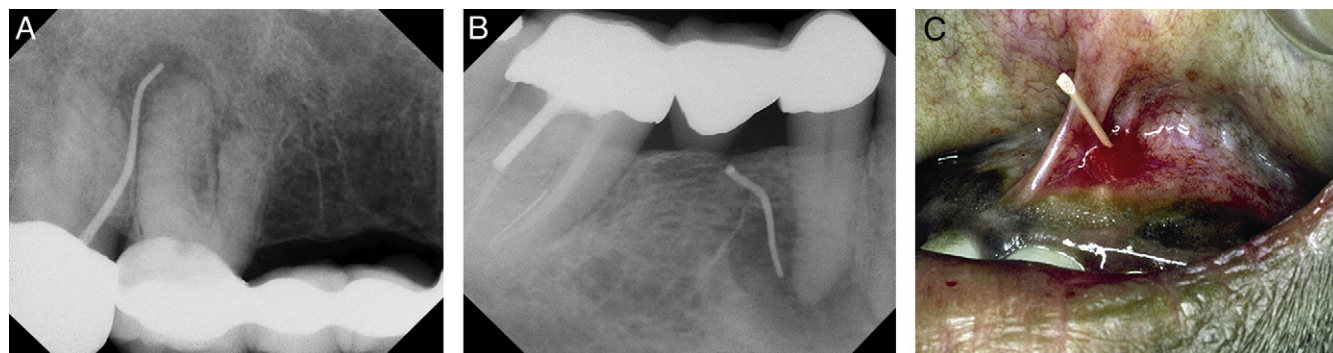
(A and B) Examples of teeth with chronic apical abscess exhibiting traceable sinus tracts as can be seen on the radiographs. Historically, this was known as suppurative periodontitis or chronic alveolar abscess. (C) Clinical photograph showing the presence of a double sinus tract tracing.
